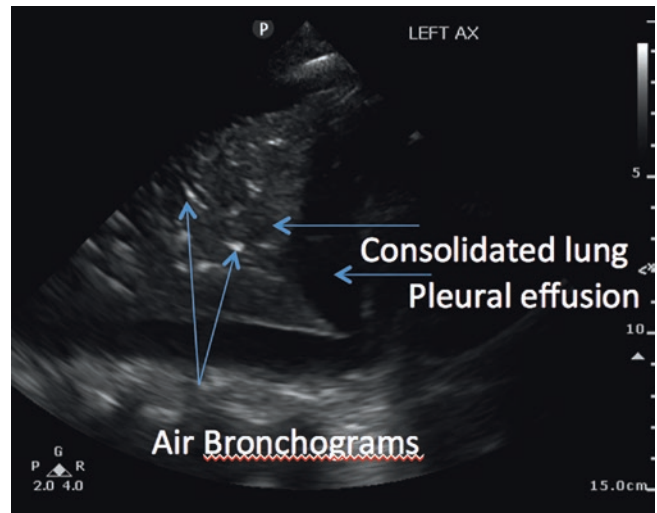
Lung ultrasound for detection of pleural effusion. Pleural effusion is seen as an anechoic space. The underlying lung appears consolidated with areas of hyperechoic signal corresponding to air in the bronchi—the so-called ultrasound air bronchogram. This patient had pneumonia and sonographic-guided bedside aspiration revealed a simple parapneumonic effusion. See also Video 37.4
